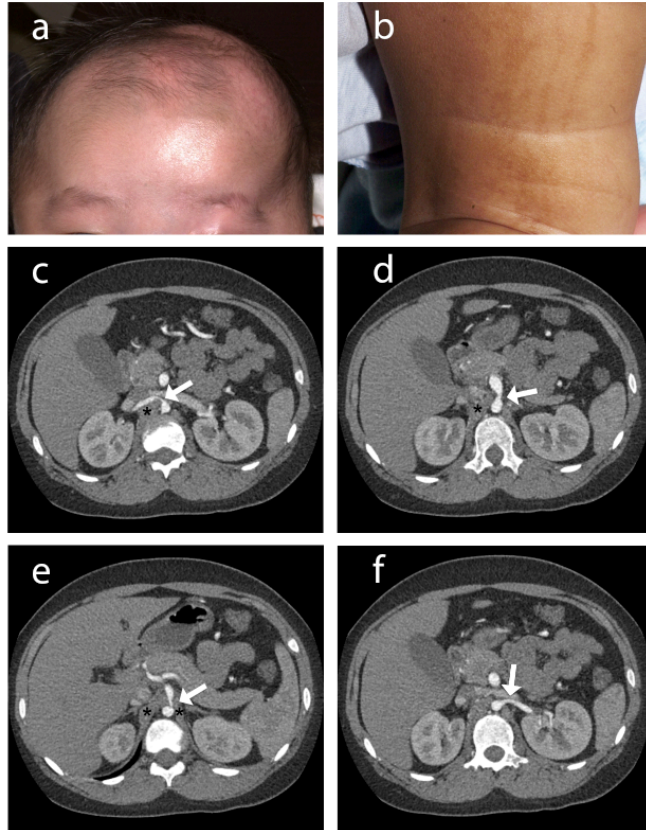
Clinical features and axial CT imaging of the proband at 4 month and 13 years respectively. (a) Photograph showing asymmetric temporal fatty masses, alopecia and a parietal fatty accumulation suspicious for nevus psiloliparus. Disrupted left eyebrow are also visible. (b) Linear hyperpigmentation of the posterior right thigh. (c) Hypertrophied diaphragmatic crus (*) indenting into the proximal right renal artery (white arrow). (d) Hypertrophied diaphragmatic crus (*) impinging the proximal superior mesenteric artery (white arrow). (e) Bilateral hypertrophied diaphragmatic crura (*) compressing the proximal celiac artery (white arrow). (f) Mild stenosis of the proximal left renal artery (white arrow) in absence of extrinsic compression.
